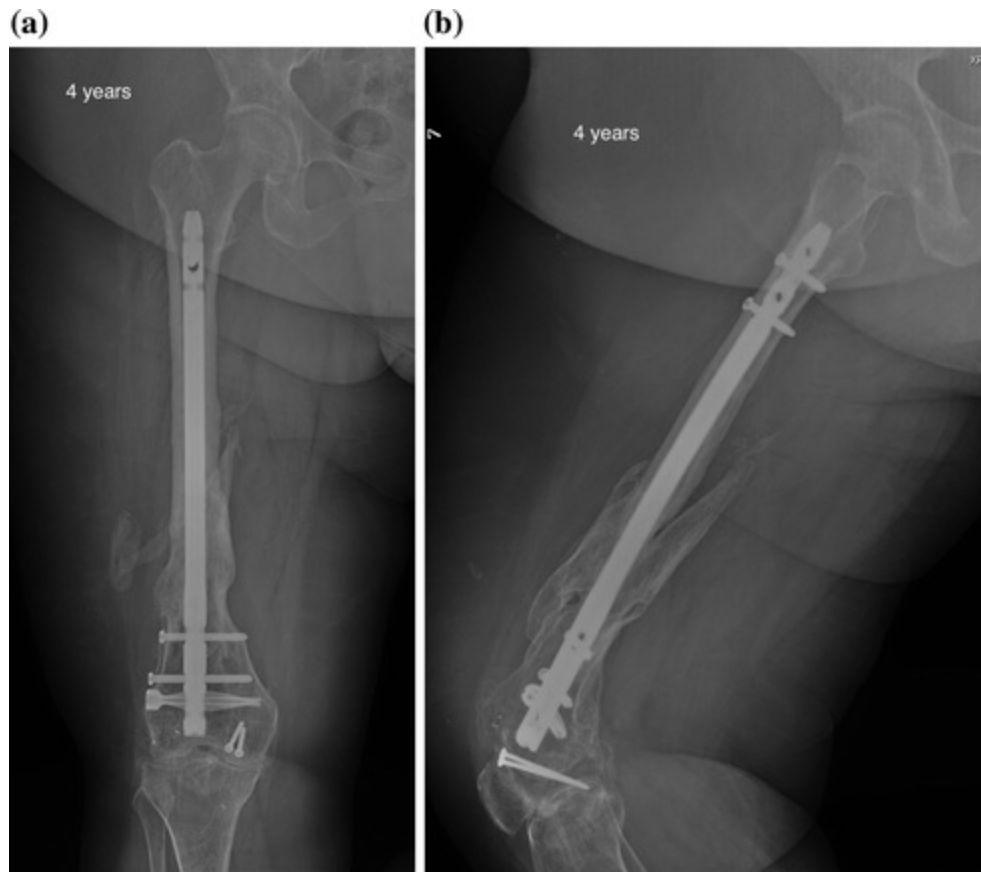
Last follow-up a anteroposterior and b lateral radiographs of the right femur at 4 years showing resolution of the nonunion and stable hardware. There has been further consolidation across the nonunion site
